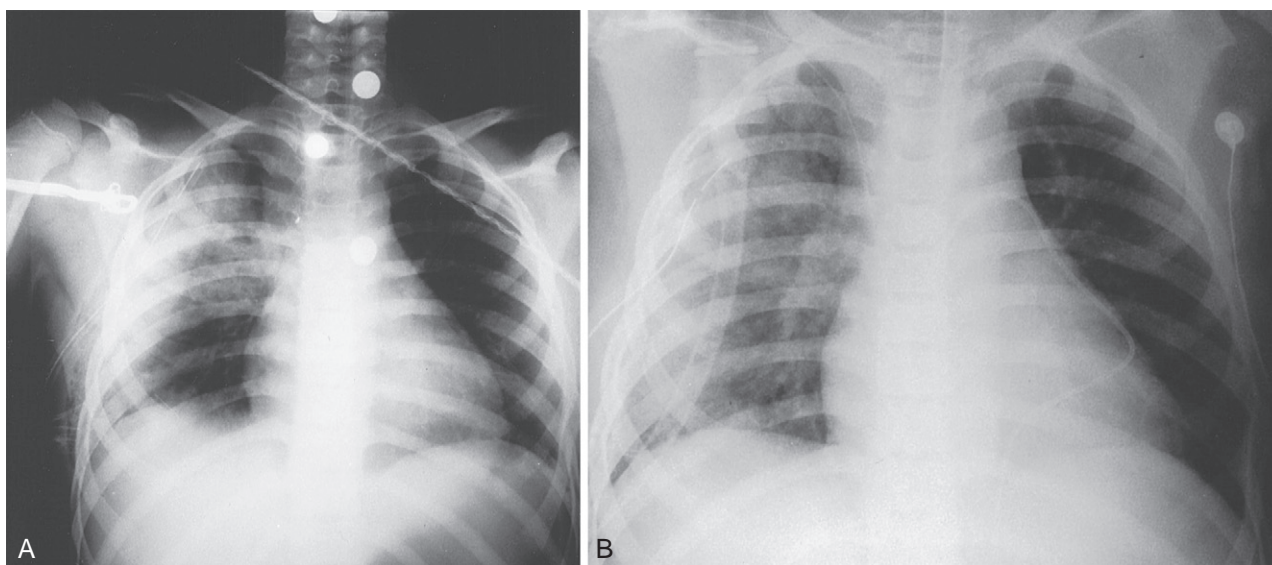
Pericardial tamponade from blunt chest trauma. The patient was a rear seat passenger in a high-speed frontal collision. Seat belt mark over lower sternum. Shock unresponsive to fluid. Pericardial effusion on transthoracic echocardiography. A, Normal heart on plain chest radiograph with evidence of pulmonary contusion. B, Chest radiograph after catheter drainage of bloody pericardial effusion. No further treatment was required. (From Wesson DE: Trauma of the chest in children. *Chest Clin North Am* 1993;3:423-441. Used with permission.)
